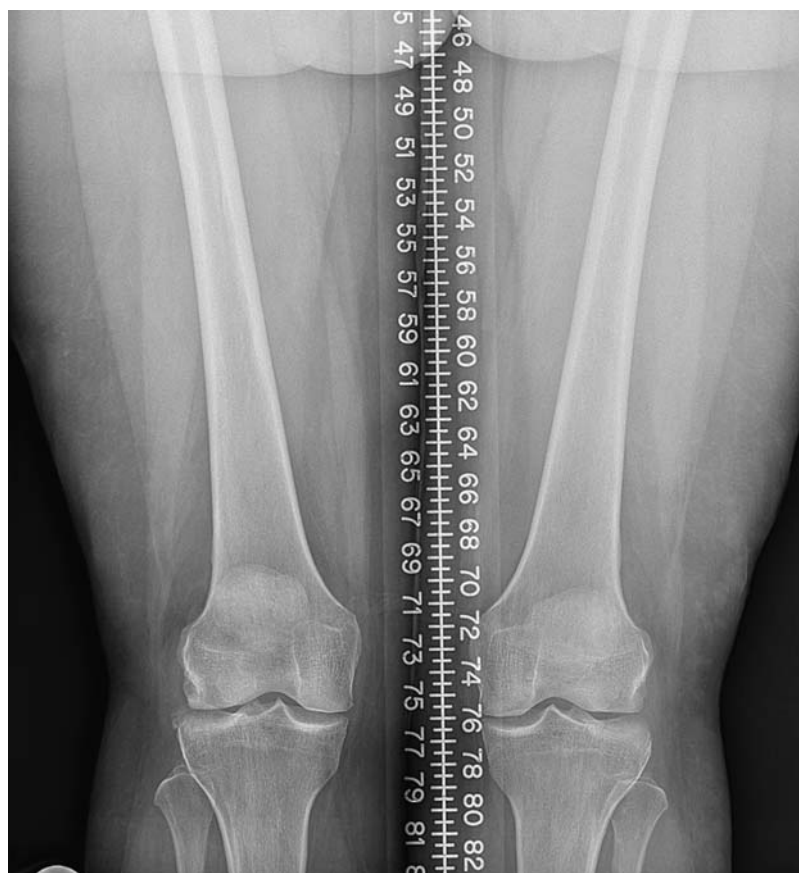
A right knee preoperative anteroposterior full weight-bearing radiograph of a 56-year-old female with lateral compartment degenerative changes.
